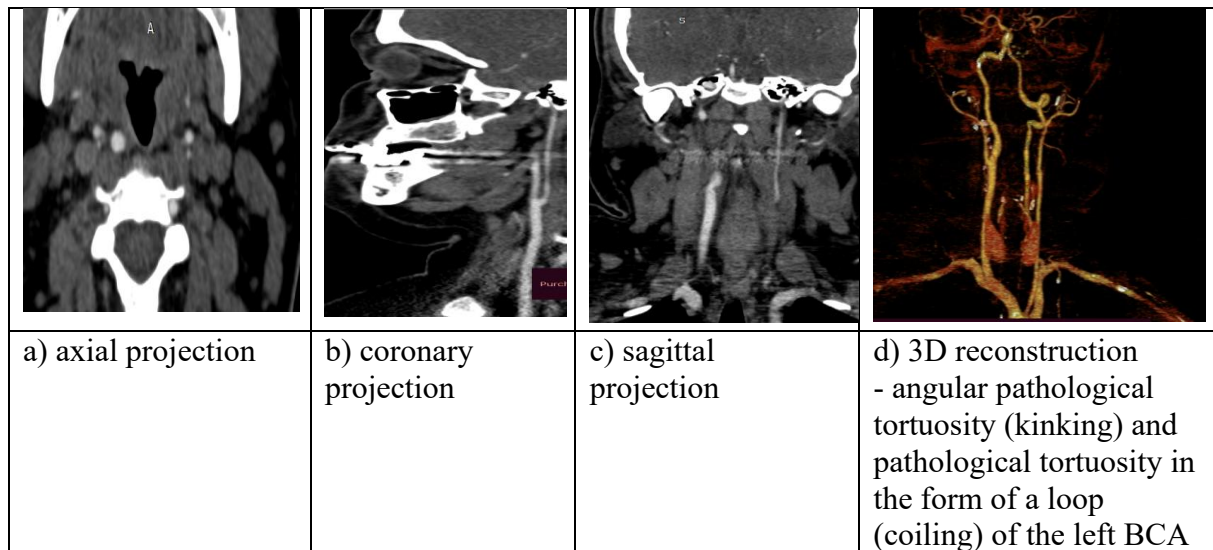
Female patient, 27 years old. Moyamoya disease. CT angiography of the extracranial vessels of the brain prior to surgery. Hypoplasia of the left internal carotid artery.
